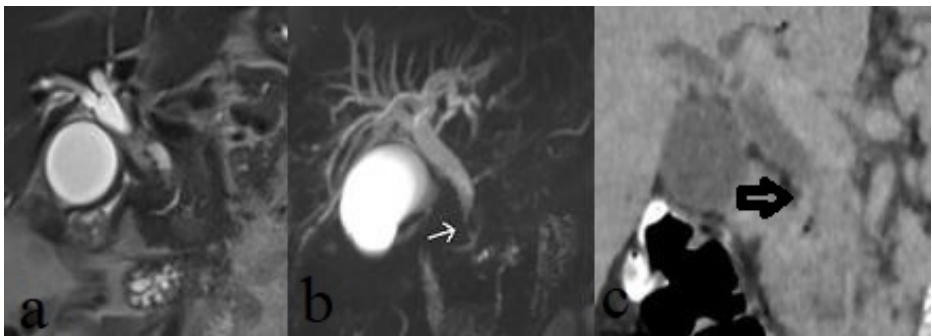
A male patient, age 56, with acute cholangitis. Coronal T2-weighted (a) and MRCP (b) images demonstrate an increase in wall thickness (white arrow) in the distal common bile duct in conjunction with intrahepatic bile duct dilation. In coronal contrast-enhanced CT (c), an increase in thickness and accompanying contrast enhancement (black arrow) are detected at the distal end of the common bile duct.
